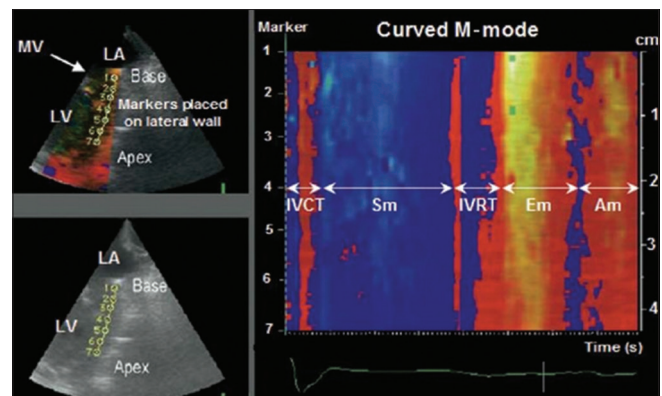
Color tissue Doppler
